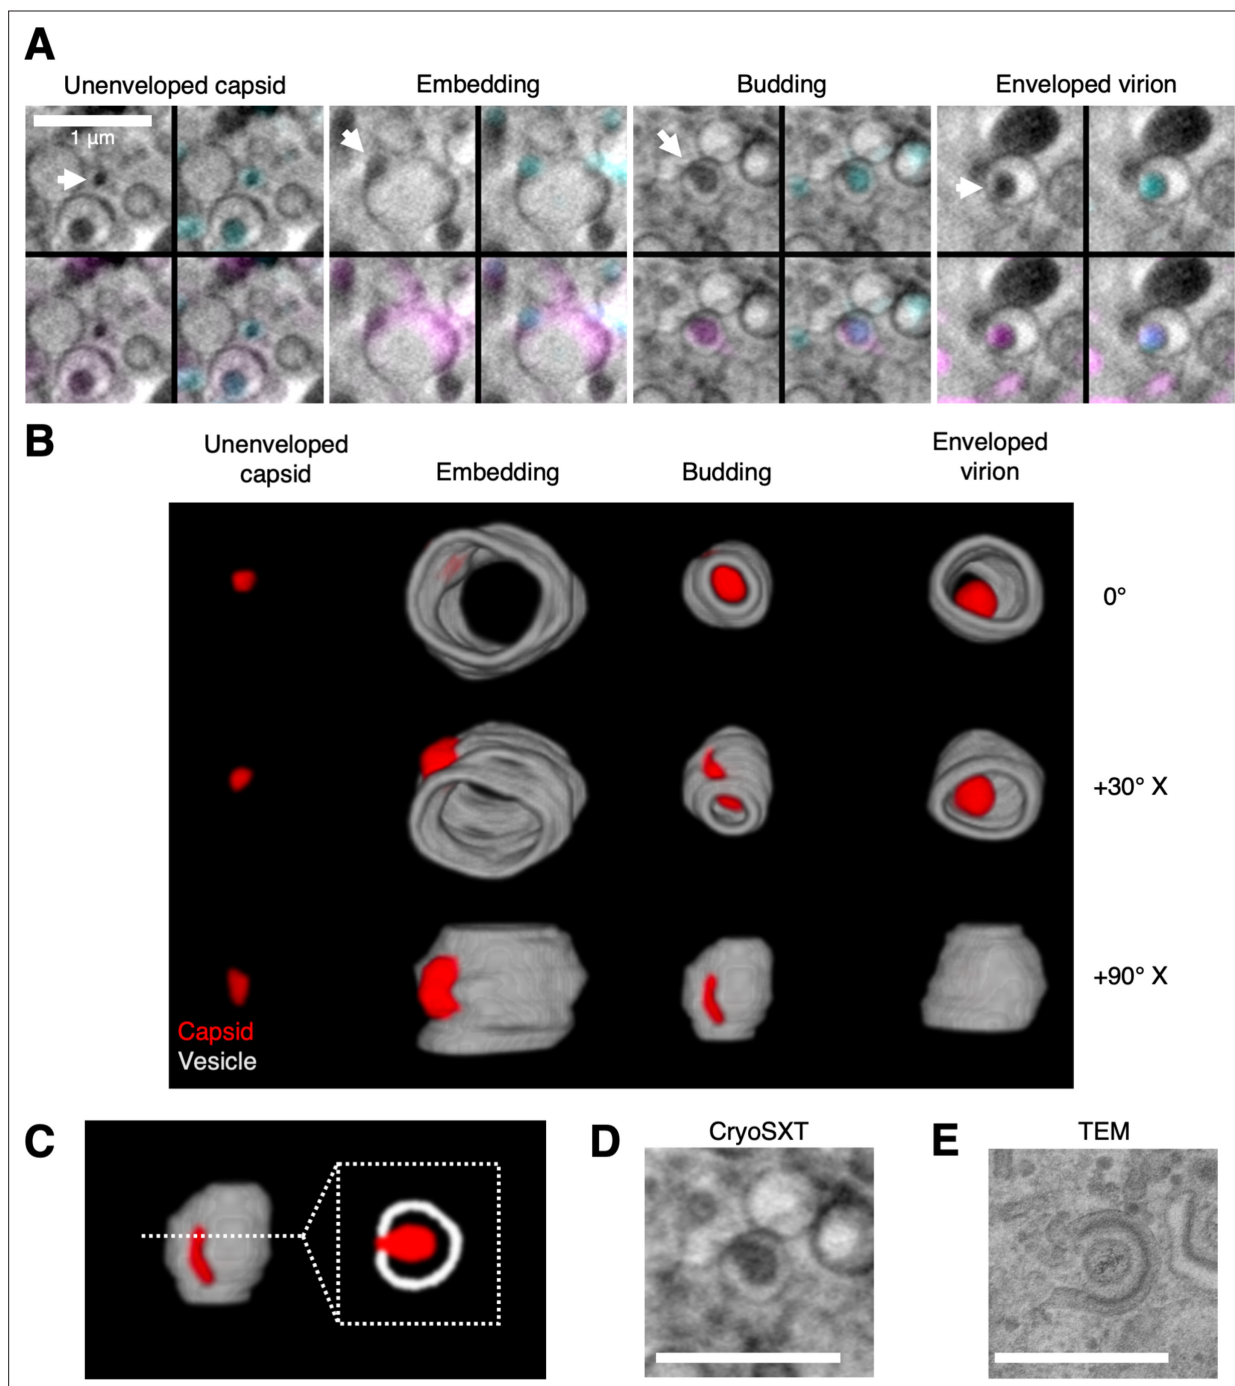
3D Snapshots of the trajectory of ΔpUL51 HSV-1 envelopment within the cytoplasm. U2OS cells were infected at MOI = 2 with ΔpUL51 HSV-1 for 16 hr. (A) Correlative light X-ray tomography (CLXT) revealed multiple stages in the assembly of the ΔpUL51 virus (arrows). (B) 3D renderings of the assembly stages captured by CLXT in A at different rotations around the X-axis. The vesicles appear open-ended because the anterior and posterior faces lack sufficient contrast for reliable segmentation — a result of the X-ray tilt series spanning 120° rather than 180°. (C) Capsids can be seen budding into vesicles. A cross-section through the middle gives the appearance of a capsid being wrapped by a tubular membrane. (D) A 2D cryo-soft-X-ray tomography (CryoSXT) projection of an envelopment event. (E) A 2D TEM of an envelopment event from an HFF-hTERT cell infected with an untagged wild-type (WT) HSV-1 (KOS strain). Scale bars = 1 μm .
